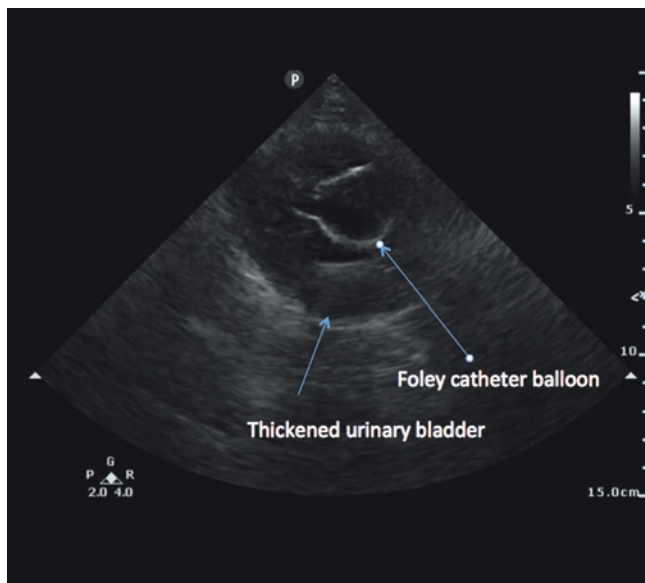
Bedside ultrasound in a patient with urosepsis. A point-of-care ultrasound was performed in a 70-year-old male who was admitted with urosepsis and gram-negative bacteremia. The figure demonstrates the thickened urinary bladder with a Foley catheter in place which prompted a urology evaluation. See also Video 37.8
